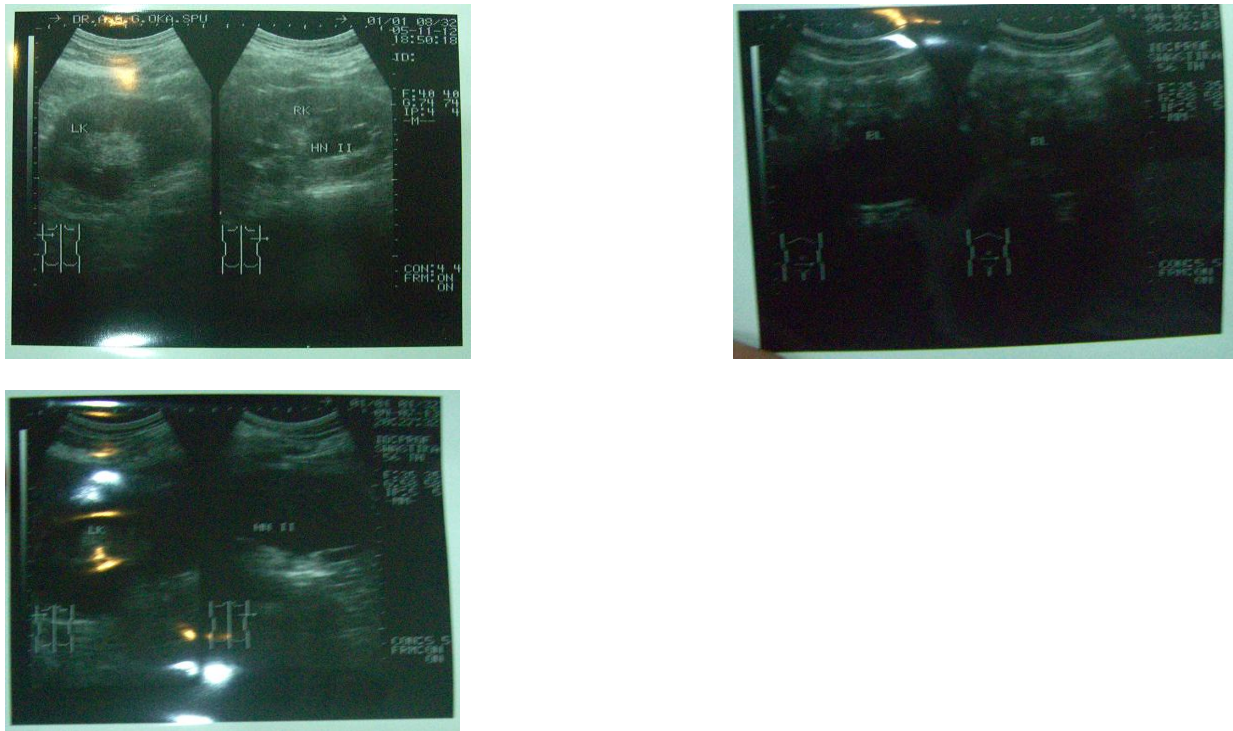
Urological ultrasound of the patient.
